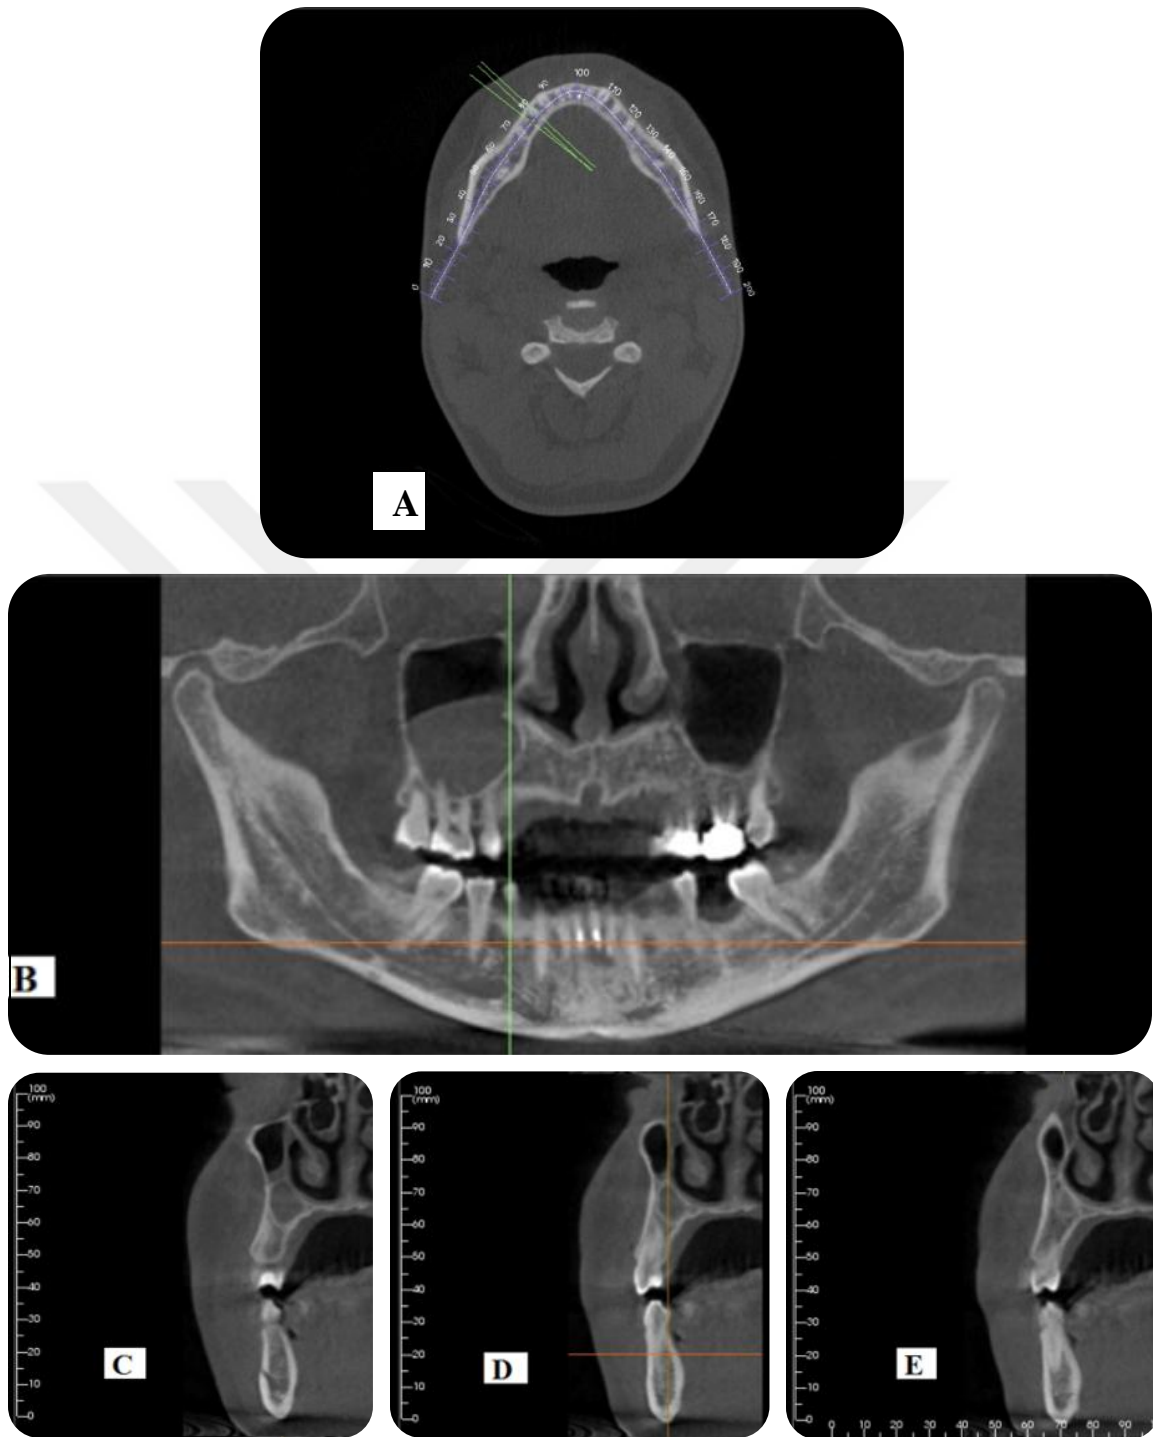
Multi-planar Reformation Arch Section. A: an axial image with sites of cross-sections on the right side. B: a reformatted panoramic view and serial cross-section 2 mm-interval sites. C, D and E: the cross-sectional images presented at the cross-section sites on the right side, which are shown on the axial and panoramic images. The axial and panoramic images are used as reference images to show the location of the cross-sectional images (Images obtained with i-CAT® Model 17-19; CBCT Imaging Unit: InVivoDental5 Version 5.2 Anatomage, software): Dentomaxillofacial Radiology Department; Faculty of Dentistry- University of Yeditepe.
